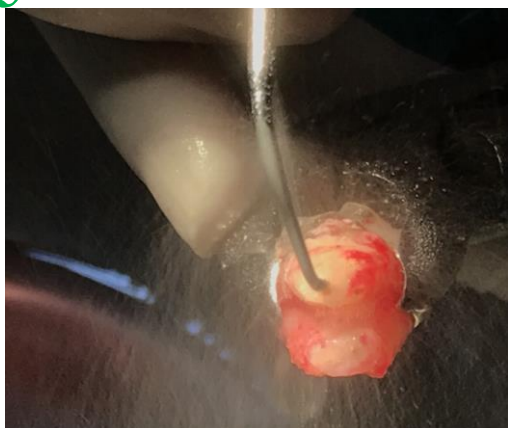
Root end preparation initiated with an ultrasonic tip.
